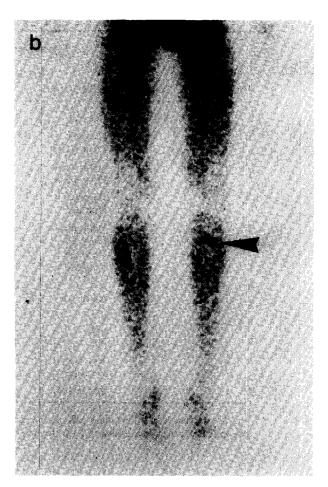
mIBG scintigraphy profile of patient no. 5 prior to antibody treatment (a) and after the fourth cycle of treatment with MAb ch14.18 (b). The tumour site in the tibia is marked with an arrow.
